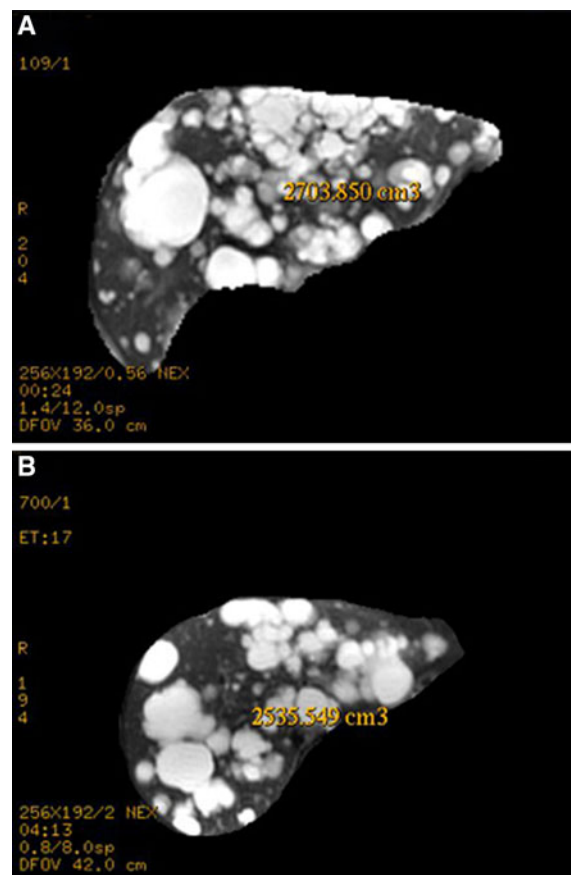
Octreotide decreased liver volume in ADPKD. MRI prior to (a) and after 12 months of treatment (b). Volumetry showed a decrease of liver volume from 2,704 to 2,535 ml
